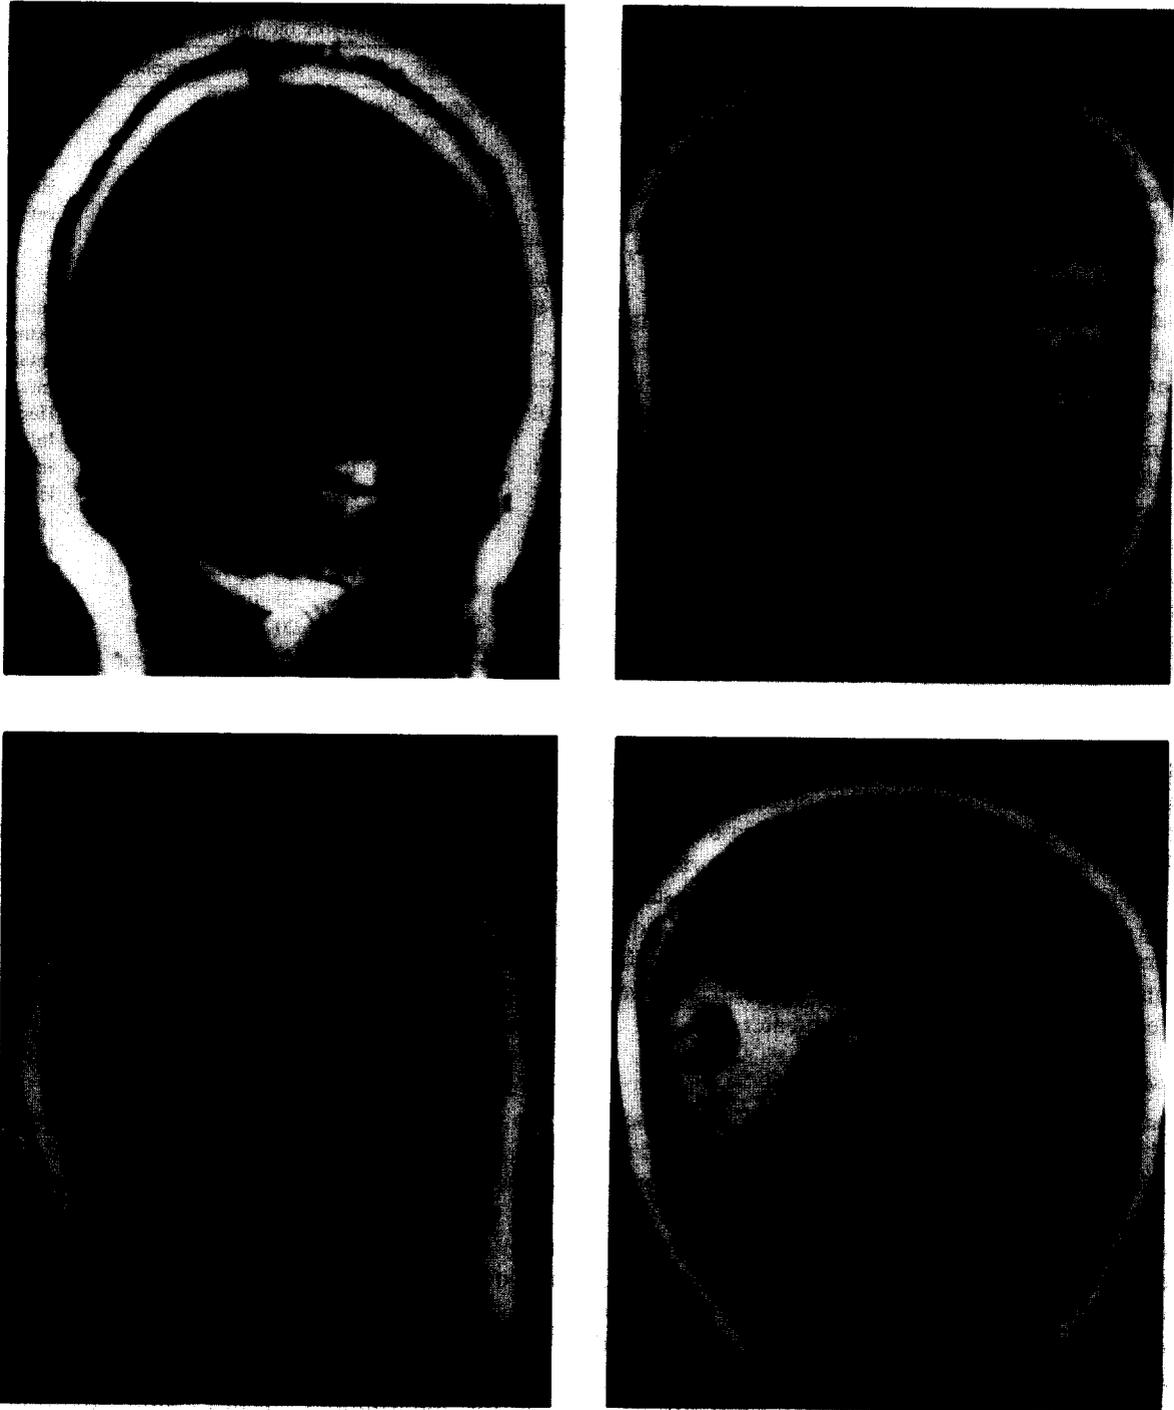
These representative coronal magnetic resonance images show cerebellar lesions in four different patients. By convention, the left side of the brain is shown on the right. Lesion locations are indicated by arrows. Shown are: (A) the left hemisphere lesion of patient BB; (B) the left hemisphere lesion of patient DL; (C) the small midline lesion of patient WE; and (D) the large left hemisphere and midline lesion of patient PC. The small arrowheads denote the lesion limit.
